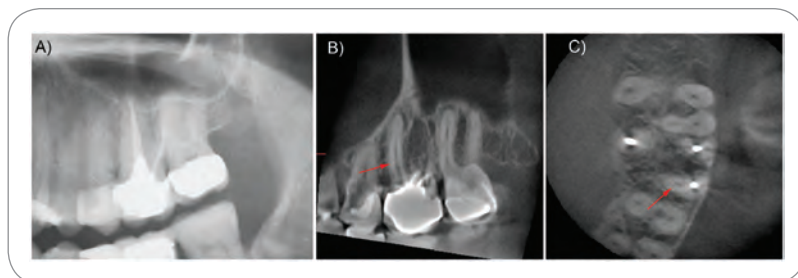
Panoramic radiograph (A), sagittal (B), and axial (C) CBCT sections of tooth No. 14. Red arrow points to the unfilled canal in the mesio-buccal root of tooth No. 14.
